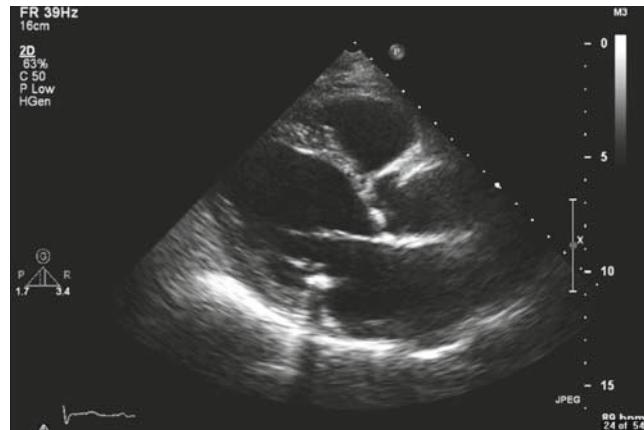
Preoperative echocardiography. Posterior mitral annular calcification is noted
